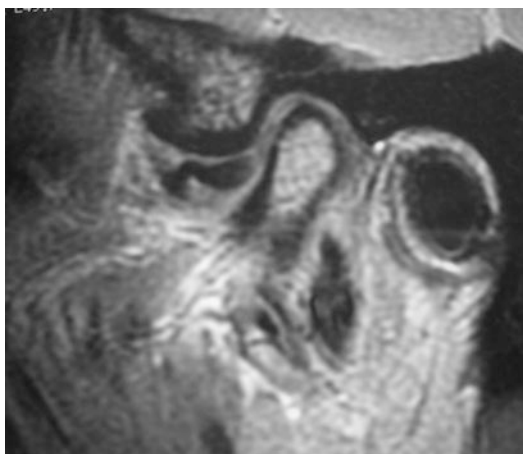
Category 4, Severe TMJ Changes—MRI showing a severely displaced and deformed disc that cannot be salvaged and hence will require discectomy
